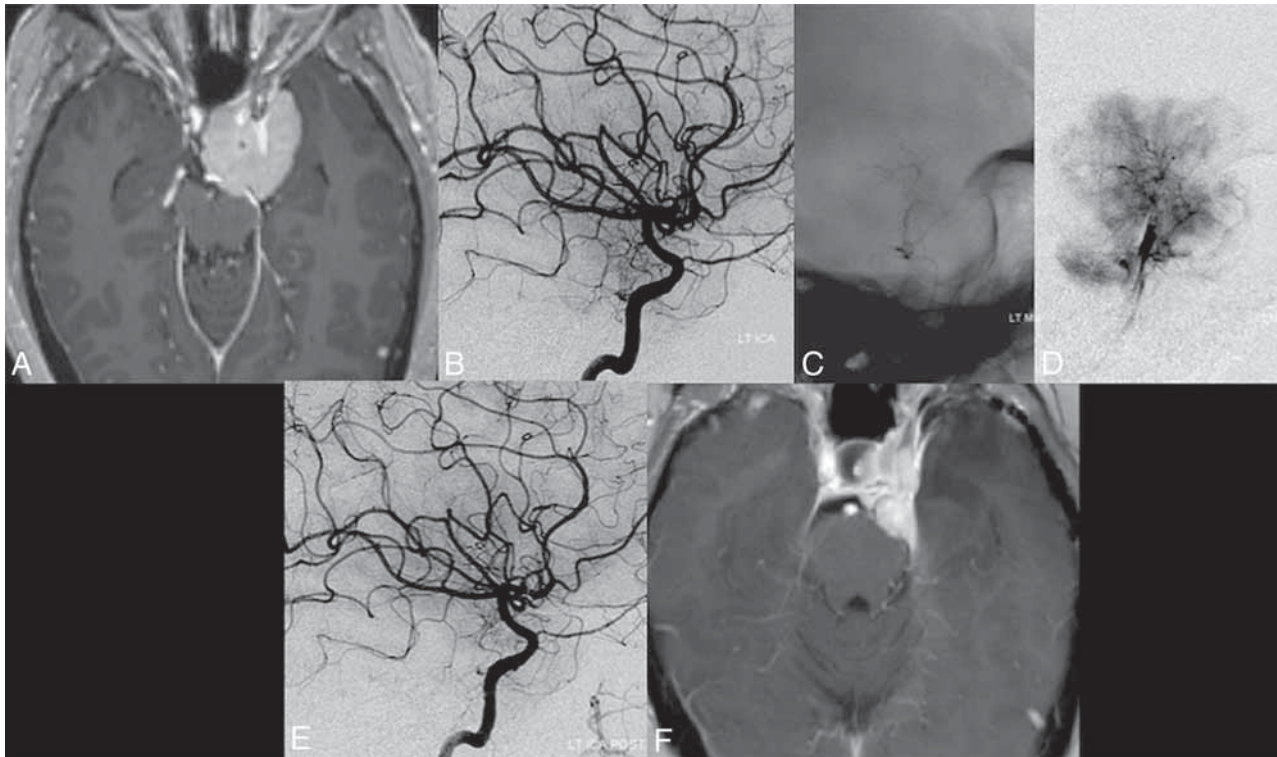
A patient with a left anterior clinoid meningioma as shown on postcontrast T1 MR imaging (A). A left ICA injection, lateral view DSA (B), demonstrates a large blush supplied by the meningohipophyseal trunk. Selective catheterization with unsubtracted (C) and subtracted (D) views with a Marathon microcatheter, followed by embolization with 45- to 150- μ m particles. A final left ICA injection, lateral view DSA (E) demonstrates 60% embolization of the tumor. A final MR imaging T1 postcontrast (F) postsurgical resection demonstrates partial excision of the mass.
